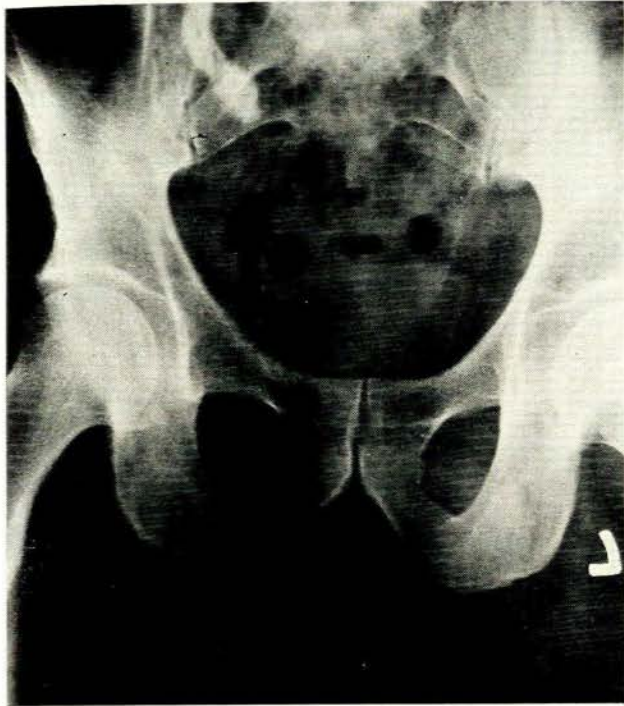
X-ray film of pelvis showing the right half of the sacrum removed by surgery.
